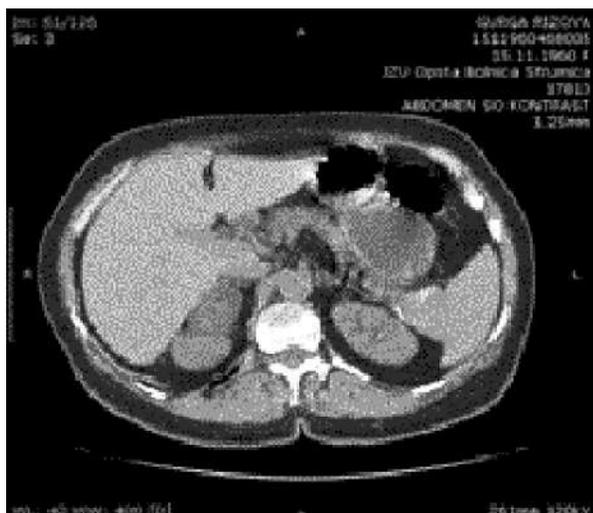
Abdominal CT scan revealed heterogeneous right adrenal mass with regular margins
